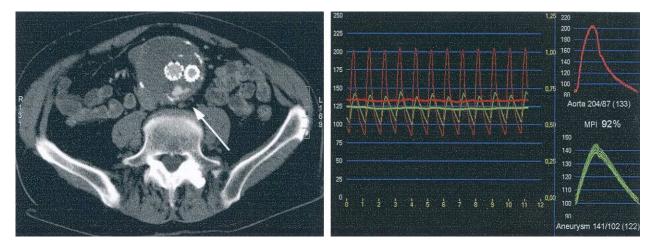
Computed tomography scan and recordings from direct intra-aneurysm sac pressure measurement in a patient with type II endoleak. A 6-mm abdominal aortic aneurysm diameter increase had occurred in the 23 months after endovascular aneurysm repair. Mean pressure index was 92%. *Red curves* represent the aortic pressure, and *green curves* represent the intra-aneurysm-sac pressure.
